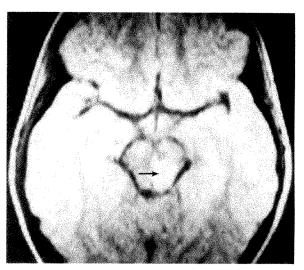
(Guy and associates). Case 2. Magnetic resonance imaging shows lesion (arrow) in left dorsal midbrain on T_2 -weighted image.
